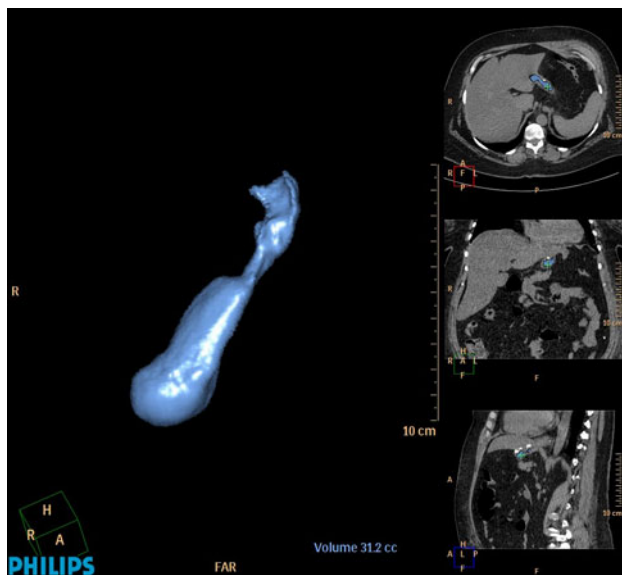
Gastric sleeve volume measurement after LSG, 4 days after surgery, using a 64-channel multidetector computed tomography (CT) scanner. The total resection of the fundus can be noted
